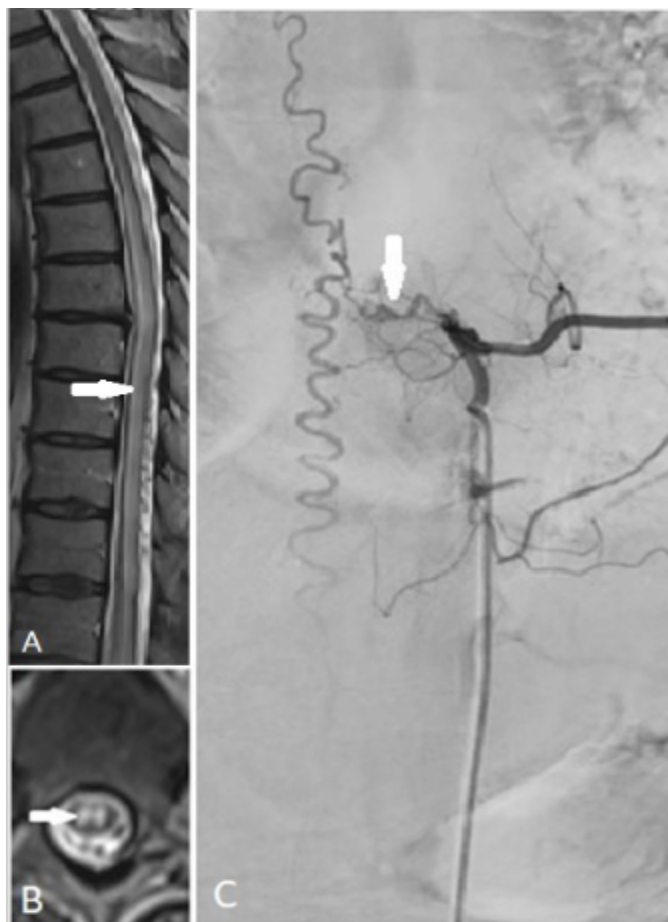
A) MRI T2 of thoracic spine showing hyperintense signal of longitudinal extensive myelopathy. B) An axial MRI demonstrating T2-hyperintensity without contrast enhancement. C) Diagnostic angiography confirming location of dural arteriovenous fistula at T4 level.
